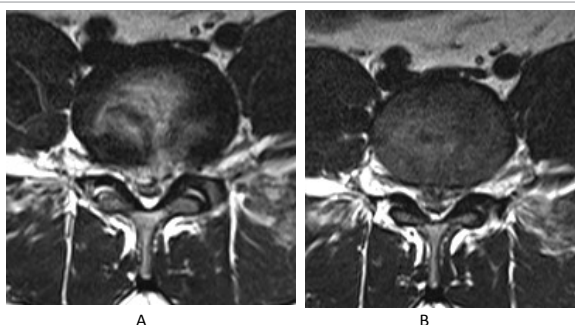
Post op MRI- T2 axial pictures at L4-5 showing decompressed thecal sac with some residual disc and small post-operative hematoma.
